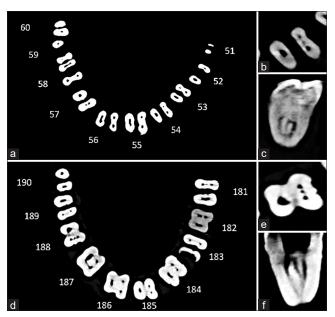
Cone-beam computed tomography scan showing the presence of the middle mesial canal in sample 54 (a), the closer axial (b) and coronal (c) views; middle mesial canal in sample 188 (d), the closer axial (e), and coronal (f) views
